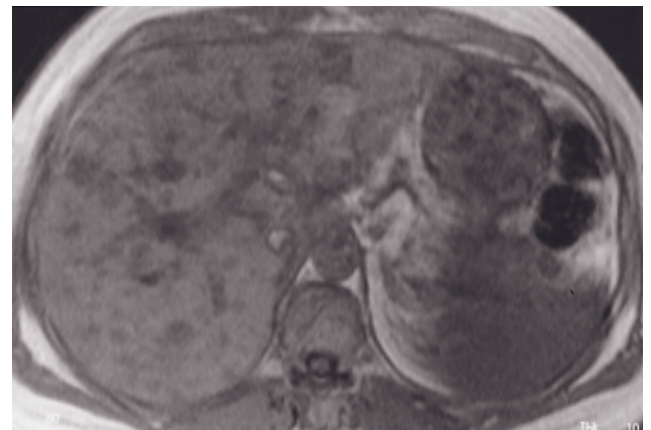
Glucagonoma and somatostatinoma with liver and spleen metastases. T1-weighted SGE (*a*) and immediate postgadolinium T1-weighted SGE (*b*) images. A 6-cm tumor (arrow, *a*) arises from the tail of the pancreas (*a*). Multiple liver metastases are present, which are low in signal intensity on the precontrast T1-weighted image (*a*). On the immediate postgadolinium T1-weighted SGE image (*b*), the primary tumor enhances heterogeneously. Intense ring enhancement is present in many of the liver metastases, reflecting hypervascularity. Note that the liver metastases are variable in size and shape.
